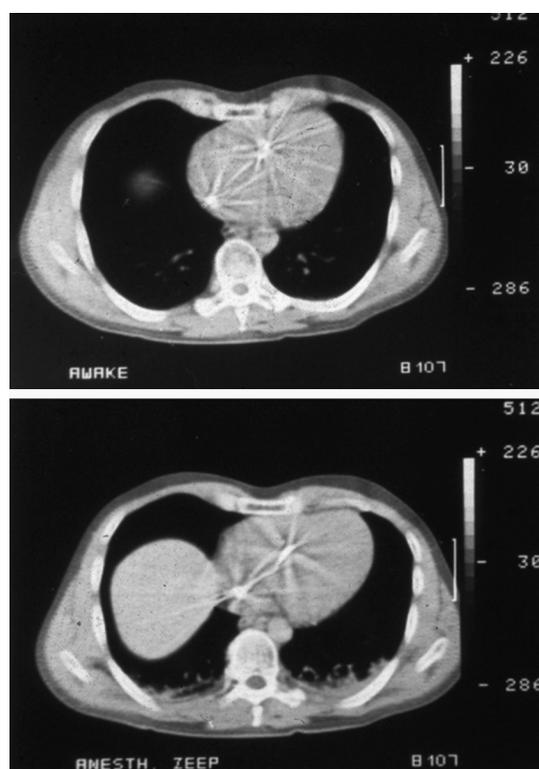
Computed tomography with transverse exposures of the chest when the subject is awake (upper panel) and anesthetized (lower panel). In the awake condition, the lung is well aerated (radiations from a pulmonary artery catheter are seen in the heart). During anesthesia, atelectasis has developed in the dependent regions (grey/white irregular areas). The large grey/white area in the middle of the right lung field is caused by a cranial shift of the diaphragm and the underlying liver.
